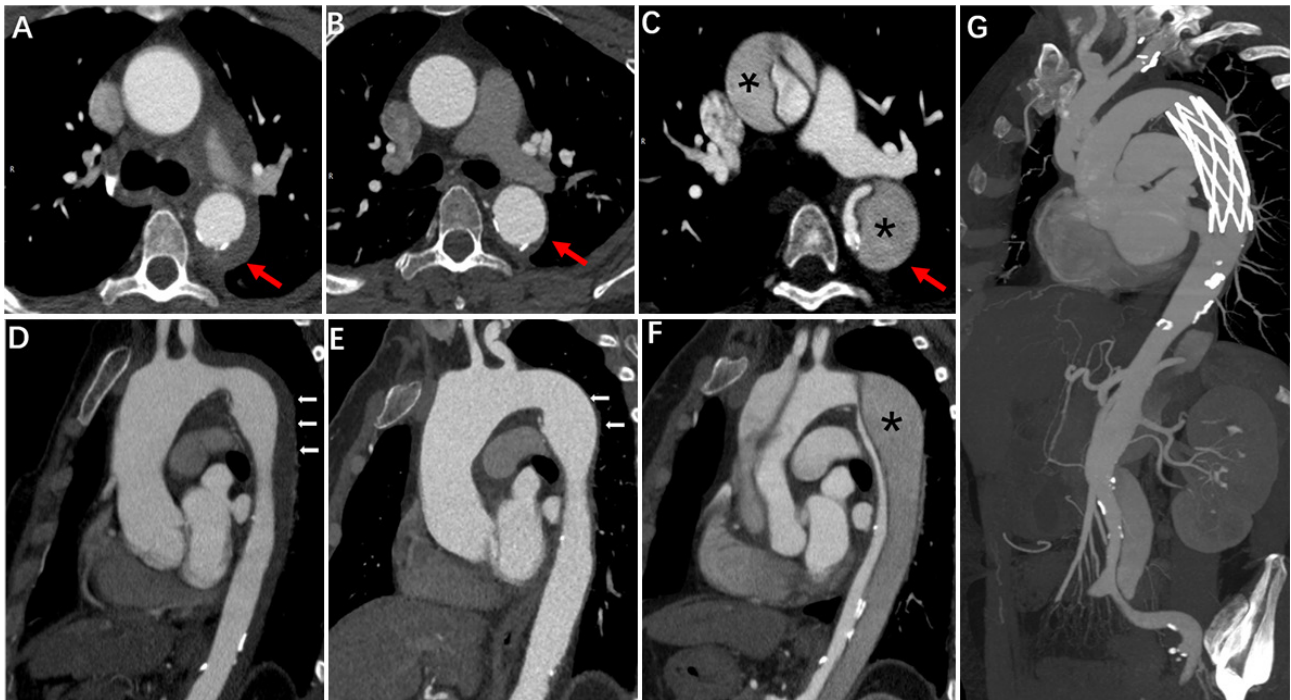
The evolution of an intramural hematoma to dissection over a 110-day period. (A and D) show the acute phase; initial computed tomography showed characteristic crescent wall thickening in the descending aorta (red and white arrows). A follow-up study 39 days later showed an obvious resolution of the hematoma (B and E). The follow-up study 110 days later revealed a typical dissection (C and F). Asterisks show the false lumens; the red arrow shows the complete resolution of the hematoma. The patient was treated with surgery. The follow-up computed tomography after the surgery (G).
